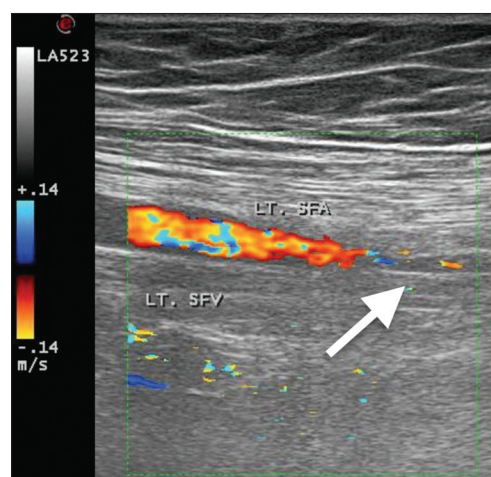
Doppler imaging of the lower limb showing complete occlusion (arrows) of the saphenous vein by an iso- to hyper-echoic thrombus with no intravascular blood flow
